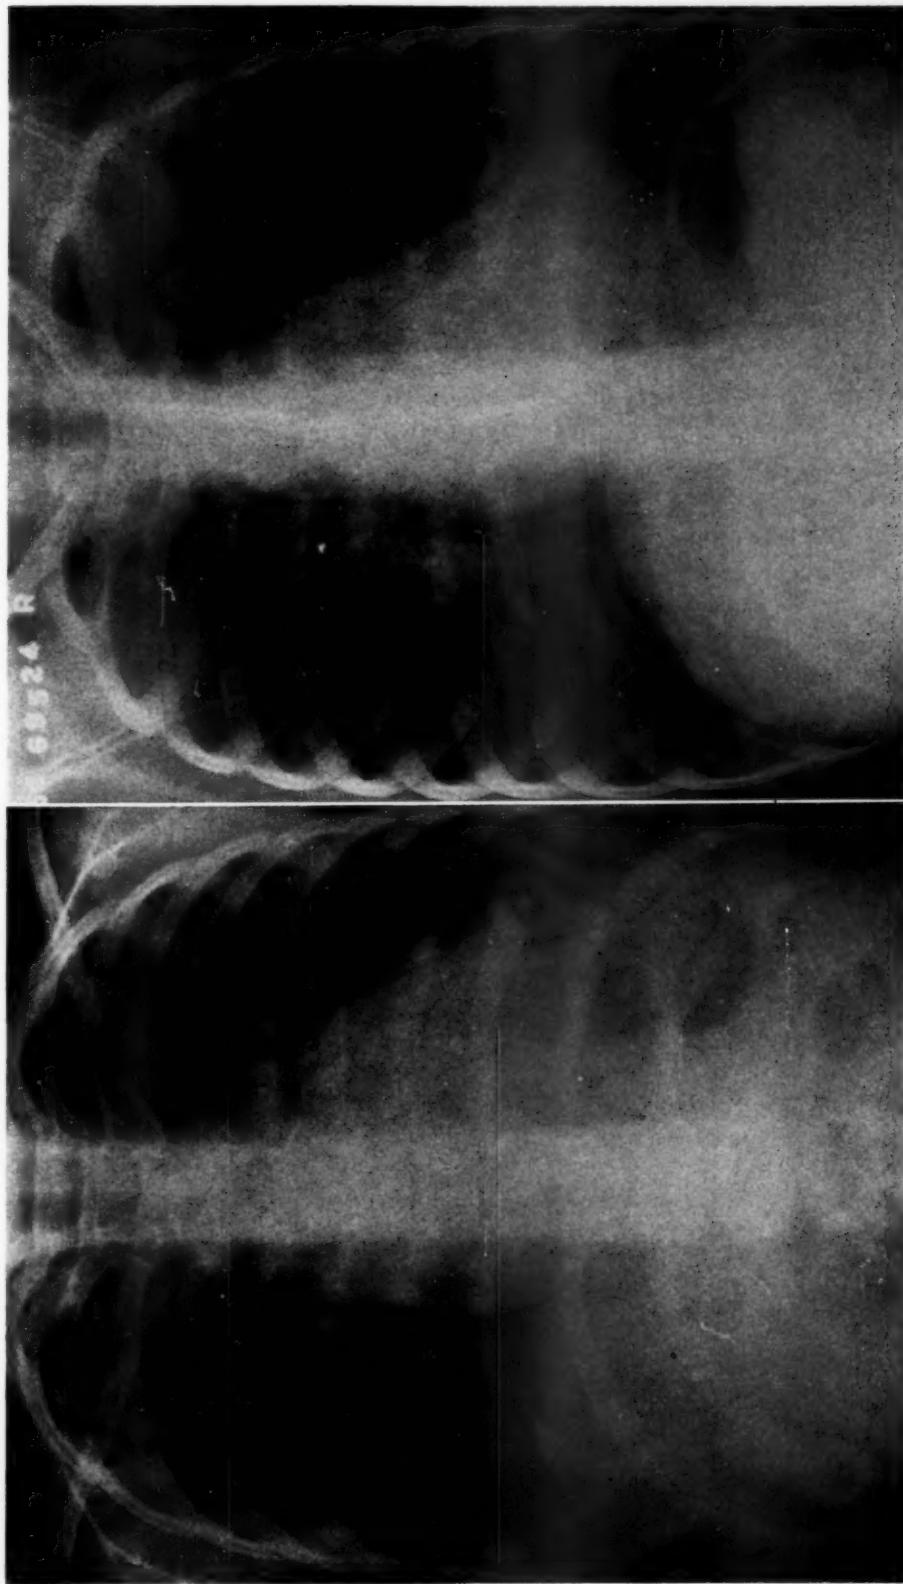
A, Posteroanterior x-ray of the chest Dec. 5, 1952. Cardiac enlargement is present. B, Posteroanterior x-ray of the chest Feb. 29, 1956. Abnormal cardiac contour is noted. An area of "inactivity" in the left anterior ventricular segment in the region of the bulge noted at the lower left cardiac border on this film was described at fluoroscopy.
